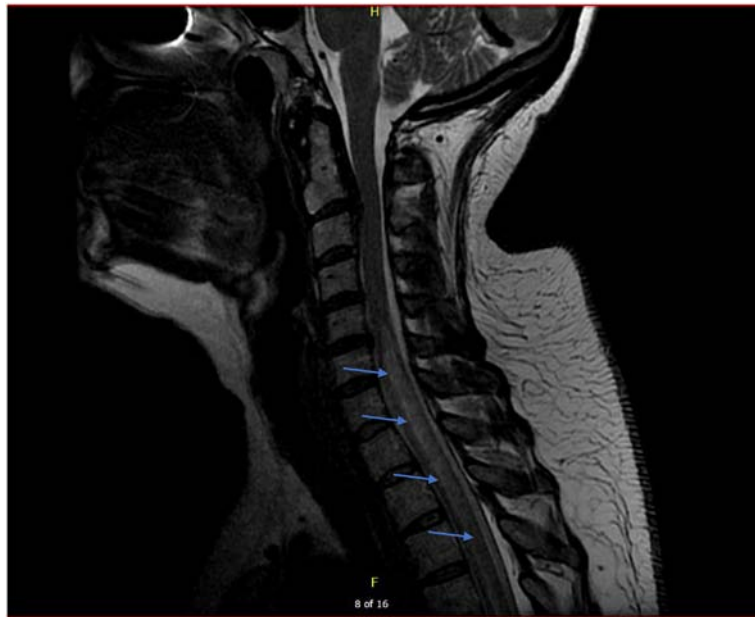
SAG T2 MRI showing cervical spinal cord edema.
